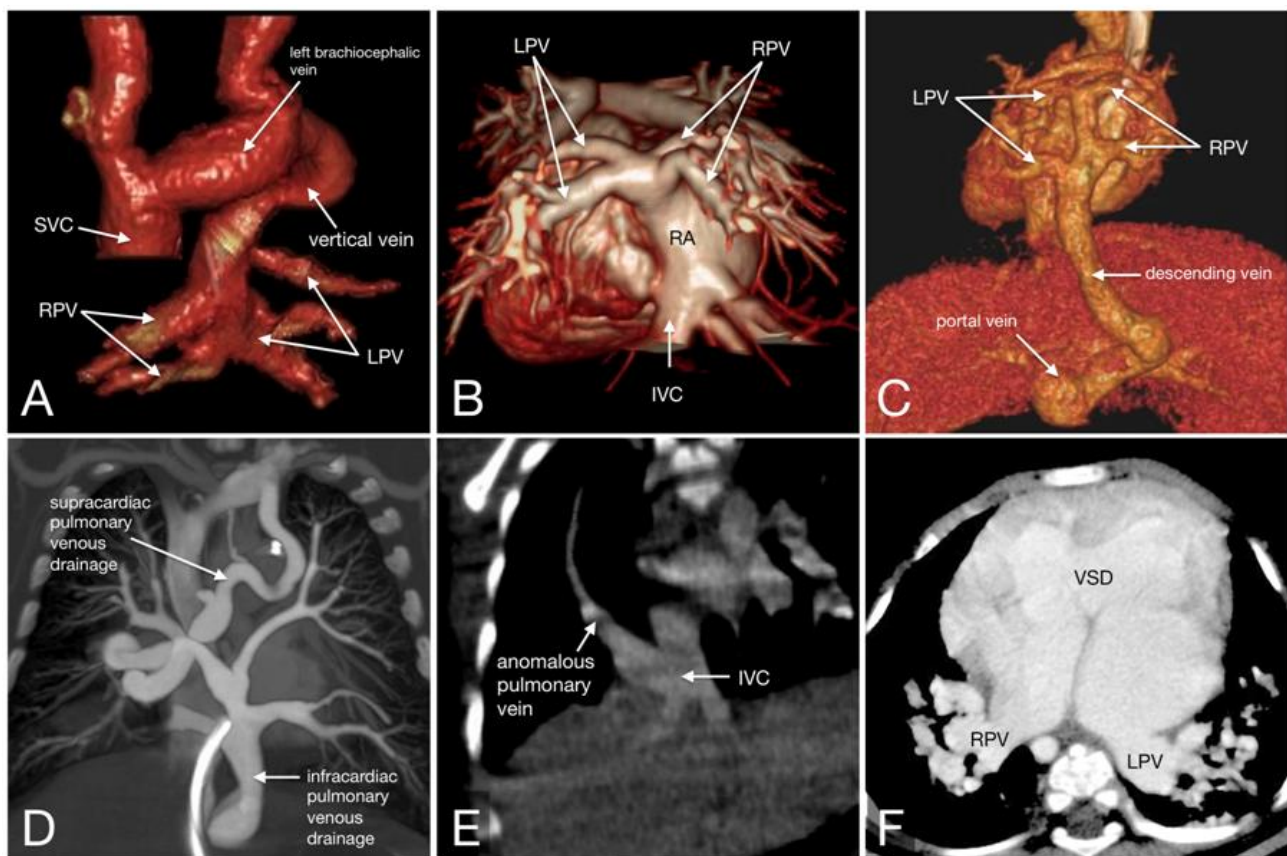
CT images of anomalous pulmonary venous connections. A, Volume rendered image (frontal view) of type I (supracardiac) TAPVR showing all pulmonary veins draining into the superior vena cava through the left vertical vein and left brachiocephalic vein. B, Volume rendered image (posterior view) of type II (cardiac) TAPVR with all pulmonary veins draining into the right atrium. C, Volume rendered image (posterior view) of type III (infracardiac) TAPVR revealing all pulmonary veins draining to a common venous channel, which descends and drains into the portal circulation. D, MIP coronal image of type IV (mixed) TAPVR with a combination of supracardiac and infracardiac anomalous pulmonary venous connections. E, Neonate with Scimitar syndrome showing the anomalous right lower lobe pulmonary vein draining into the inferior vena cava. F, Cyanotic infant with mesocardia, VSD and left atrial isomerism showing the right pulmonary vein draining into the right-sided atrium and the left pulmonary vein draining into the left-sided atrium. RPV = right pulmonary veins, LPV = left pulmonary veins, SVC = superior vena cava, IVC = inferior vena cava, RA = right atrium, VSD = ventricular septal defect.
